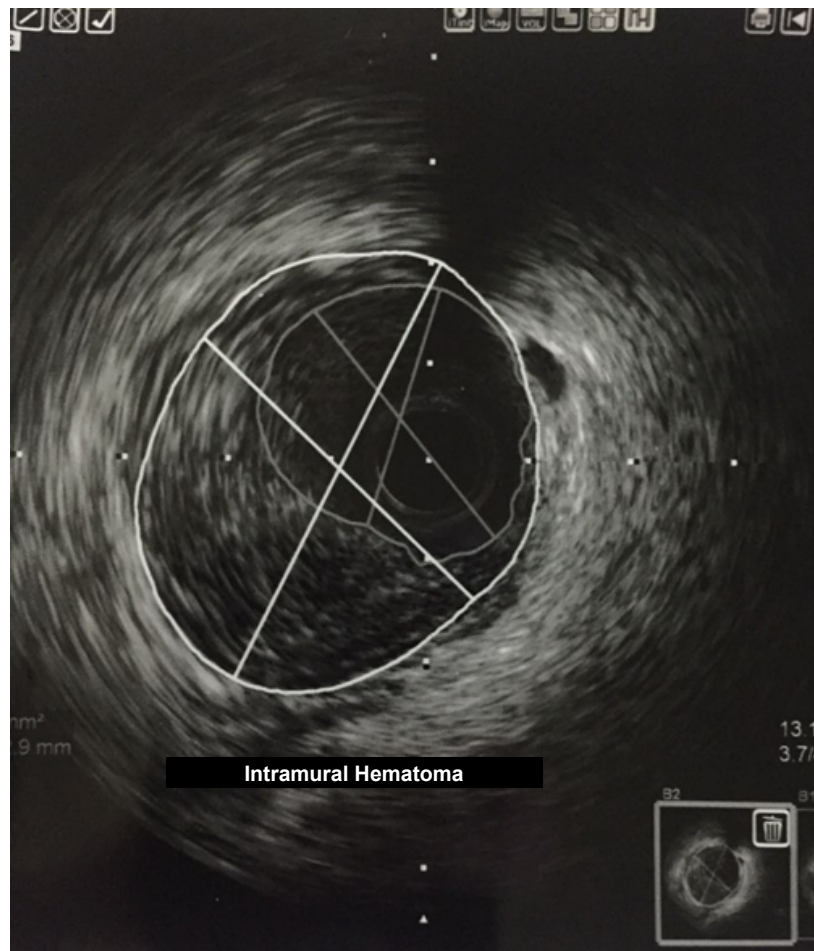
Intravascular ultrasonography of the proximal third of the anterior descending artery, performed 8 days after the first coronary angiography, showing intramural hematoma with thrombi at 4-11h.
